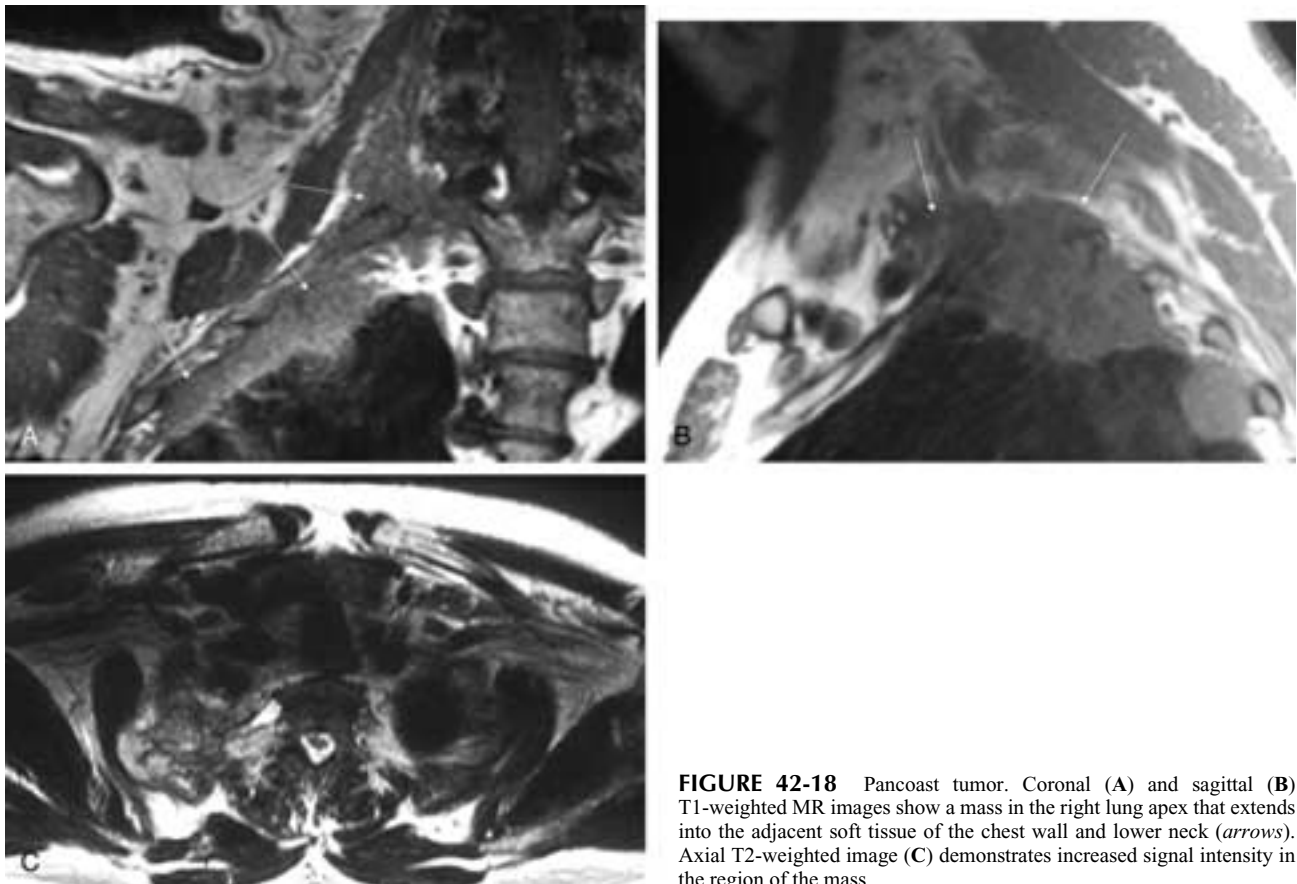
Pancoast tumor. Coronal (A) and sagittal (B) T1-weighted MR images show a mass in the right lung apex that extends into the adjacent soft tissue of the chest wall and lower neck (arrows). Axial T2-weighted image (C) demonstrates increased signal intensity in the region of the mass.
